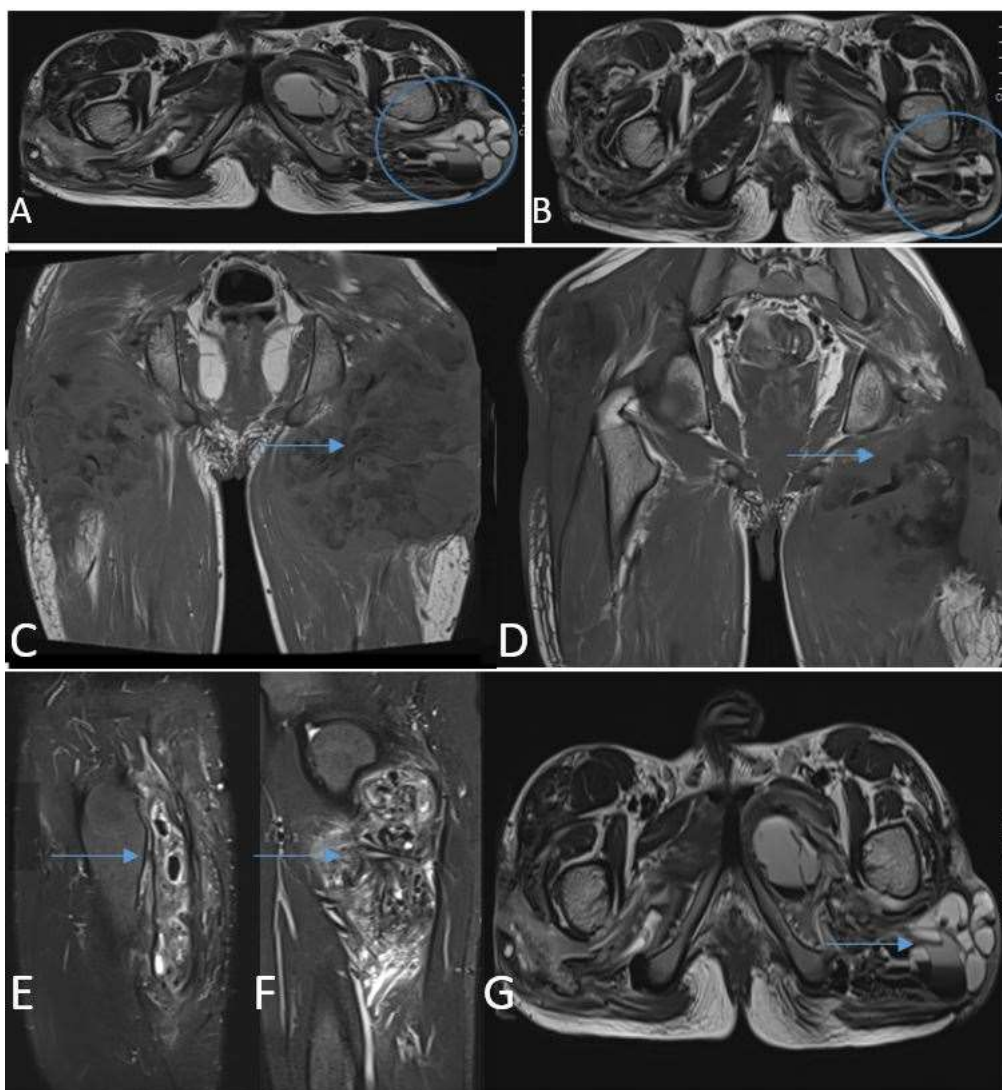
MRI of the pelvis showing two large masses in the gluteal region extending to the posterior and medial muscular lodges of the thigh in T2 hypersignal (A) and T1 hyposignal (C) with multiple lodges with liquid-liquid levels in T2 hypersignal-hyposignal (sedimentation sign) (A). These formations enhance heterogeneously after injection of contrast product, realizing the honeycomb aspect (G). Measuring approximately on the right 12x9.3x17cm and 17x9.2x17cm on the left with decrease in size between the first MRI (A,C,E,G) and the control MRI (B,D,F) after 8 months of treatment (on the right 12x9.3x17cm vs. 8x10x17cm and on the left 17x9.2x17cm vs 13x7x14cm).
